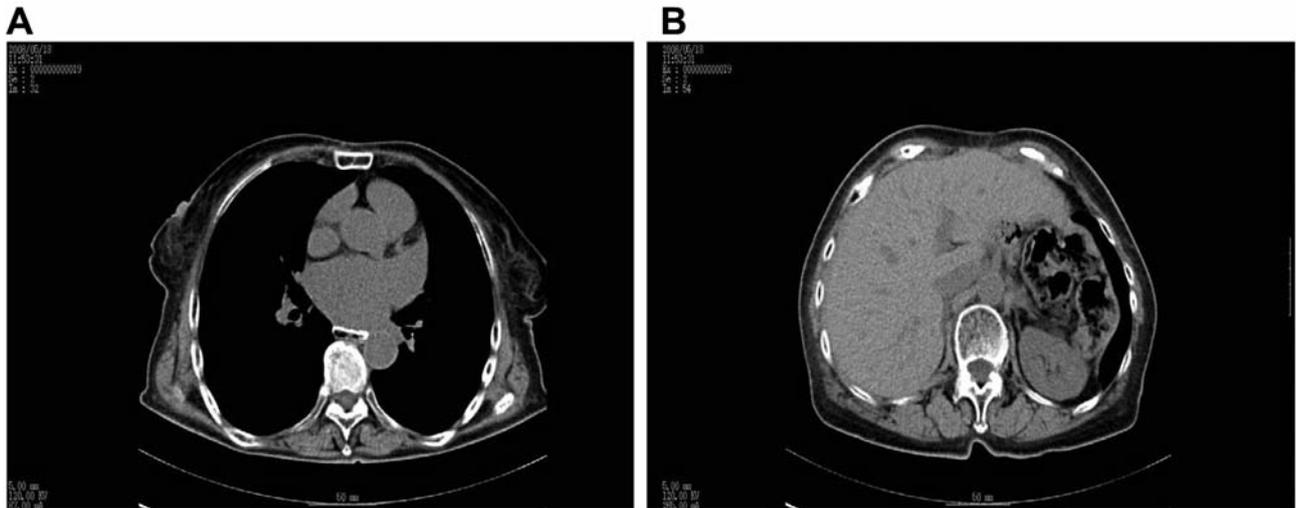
The most recent thoracoabdominal computed tomographic scan for follow-up examination showed no evidence of recurrence in the thoracic (A) and abdominal cavities (B).
